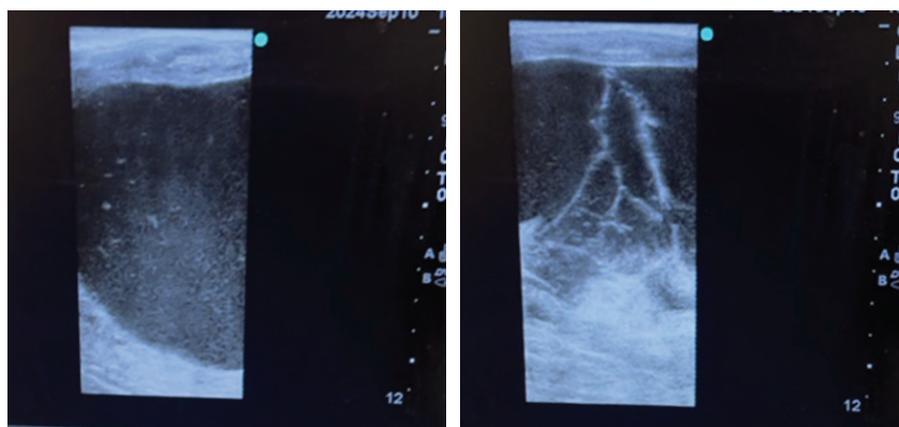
Transrectal ultrasonographic images of the abnormal structure on the left ovary immediately prior to ovariectomy. Both images are from the same evaluation of the structure but are different planes of view; note the hyperechoic appearance of the antral fluid in some fields and thin hyperechoic strands in others (only 12 cm depth is depicted, but the structure extended beyond this field)
